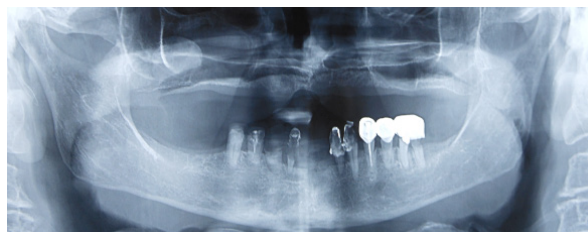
Preliminary panoramic dental X-ray. During the X-ray, the patient had acrylic FPDs in 3.3-3.2-4.2-4.3, and 4.4-4.5, which are radiotransparent.
